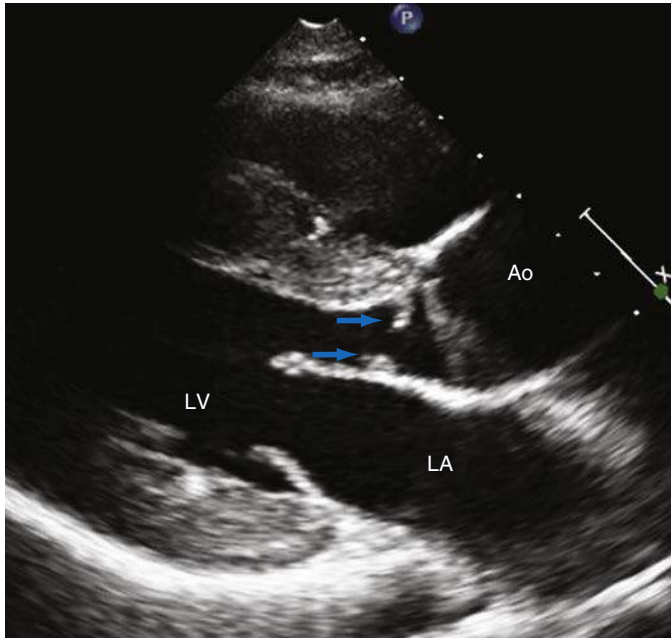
Two-dimensional transthoracic echocardiography (2D TTE) from the parasternal long axis view. *Blue arrows* show a subaortic fibromuscular ridge. *Ao*, Aorta; *LA*, left atrium; *LV*, left ventricle.
